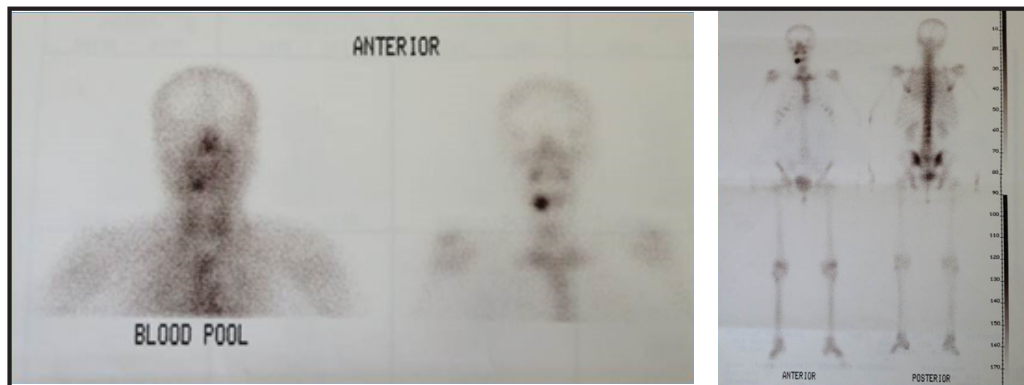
and 3B. Whole body scintigraphy revealed only involvement of the mandible but not other parts of the skeleton.
